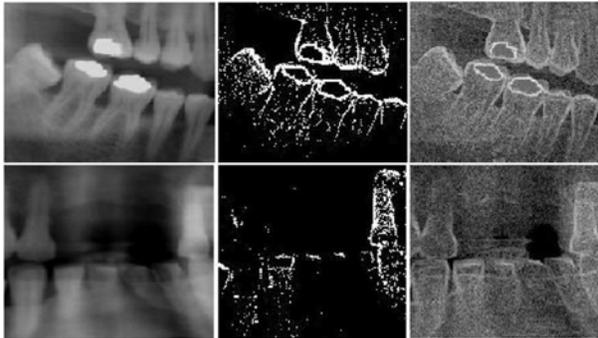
Two different samples of digital dental X-ray and the resultant images using the Bayesian classifier and wavelet fusion [2]
